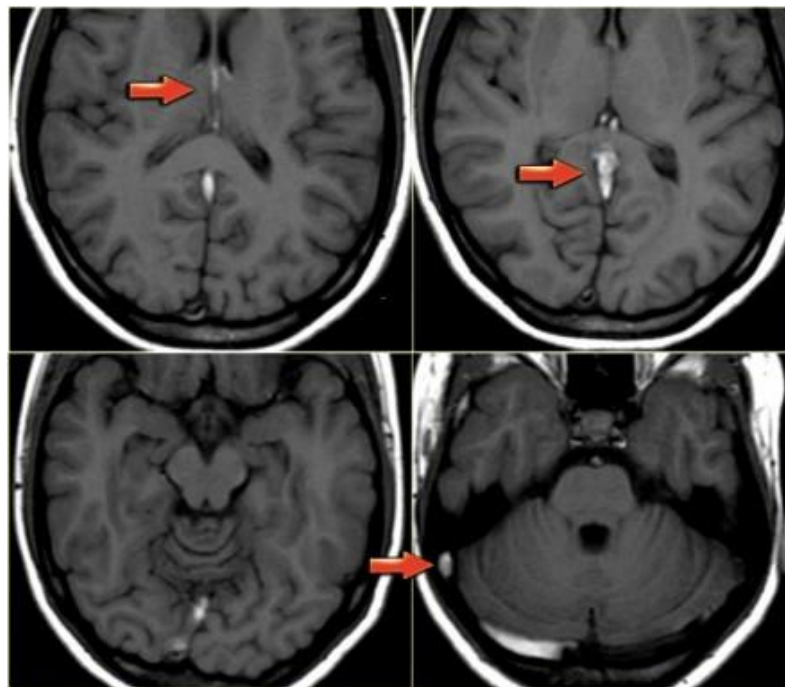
The images on the left show abnormal high signal on the T1-weighted images due to thrombosis. The thrombosis extends from the deep cerebral veins and straight sinus to the transverse and sigmoid sinus on the right. Notice the normal flow void in the left transverse sinus on the right lower image.
